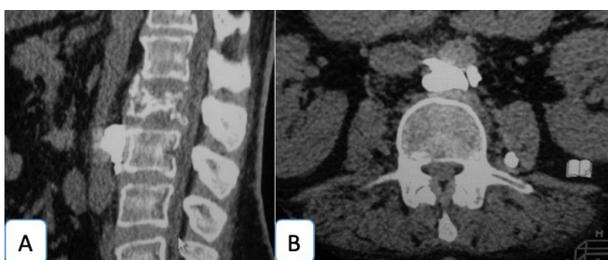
(A,B) Sagittal and axial CT lumbosacral spine of a 65 years old female with osteoporotic fracture L1. PVP was done with cement leak in front of the L2 vertebra below the fracture pushing the abdominal aorta. Clinically the patient improved and the cement leak was asymptomatic.
